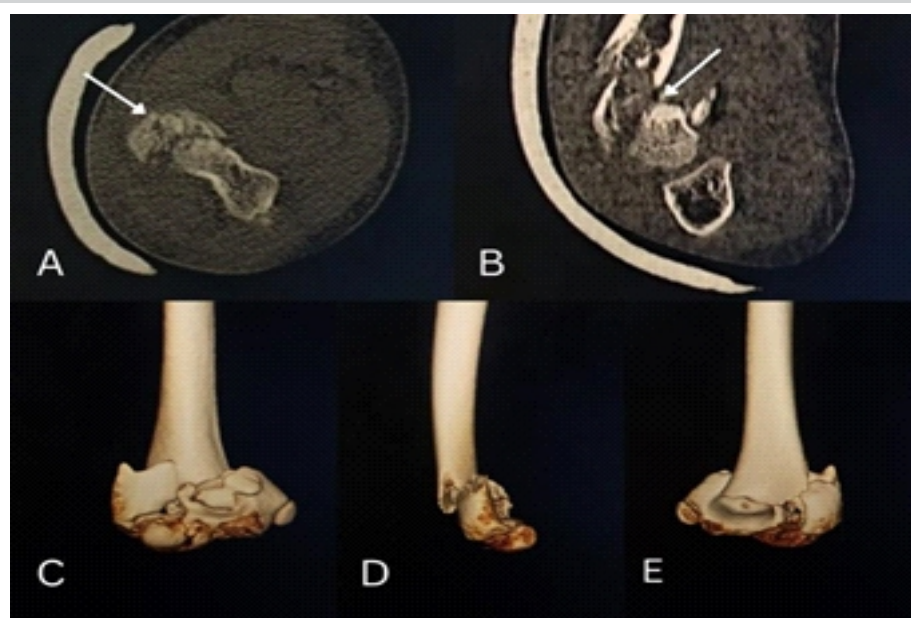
Pre-operative computed tomography (CT) images of right elbow. (a) Axial (b) sagittal view with white arrow indicating the fracture line of the T-shaped distal humerus fracture with capitulum shear fracture. (c, d, e) 3D reconstruction of the CT scan.
